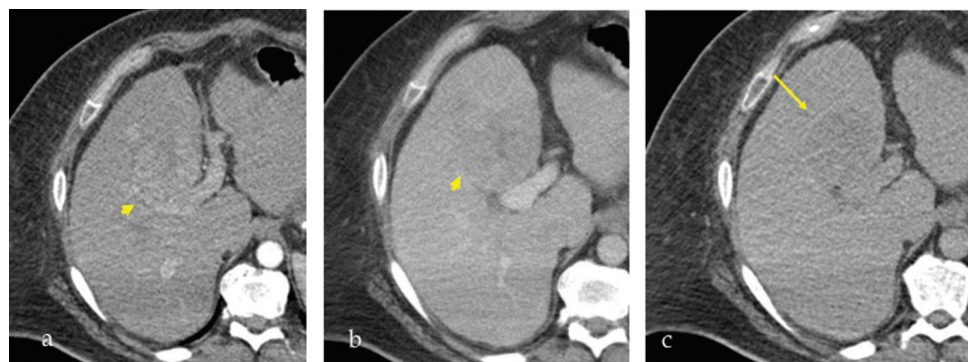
Hepatocellular carcinoma on triphasic computed tomography. a. Arterial and (b) portal phase images show hypervascularity and washout in the lesion (arrow head). c. Delayed phase shows capsule appearance (arrow).
